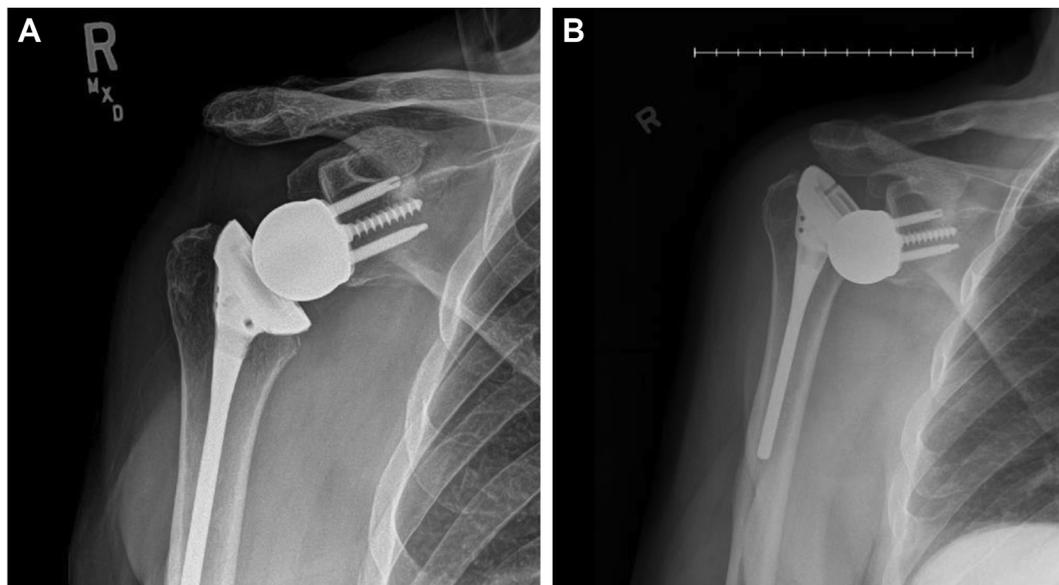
(A) Postoperative radiograph of a reverse shoulder arthroplasty. (B) Radiographically confirmed postoperative dislocation showing a dissociation of the humeral and glenoid components.
